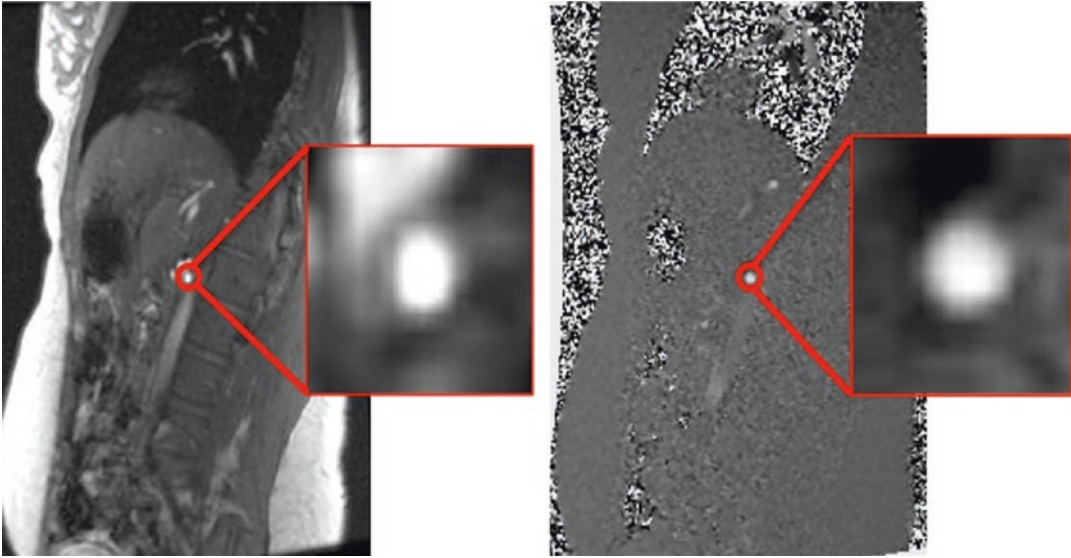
Representative magnitude (left) and velocity images (right) obtained by 2D phase-contrast MRI of the renal artery. The Figure was modified from Villa G. et al.
